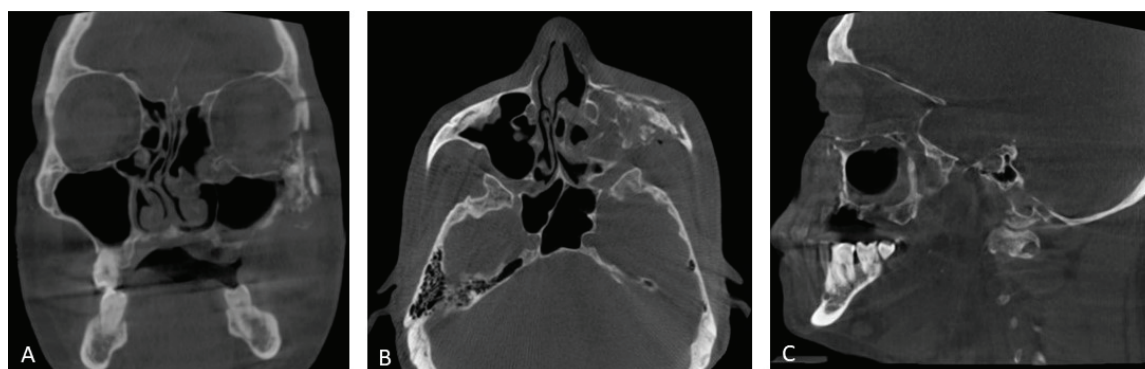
CBCT images (A) Coronal section showing the destruction of the left lateral wall of the nose, the floor of orbit, and left zygoma, (B) Axial section showing haziness in the left maxillary sinus with sequestration seen in left zygoma, (C) Sagittal section showing mucosal thickening in the left maxillary sinus with destruction of anterior and posterior walls along with the alveolar bone
